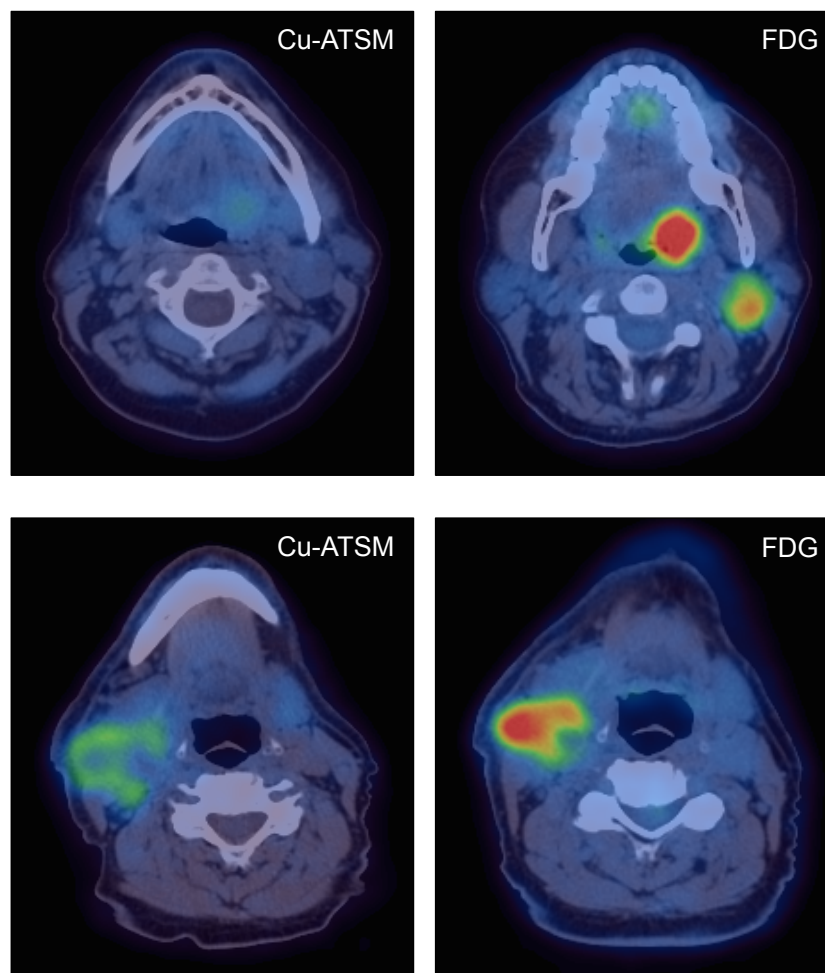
Comparison of ^{64}Cu -ATSM PET/CT with ^{18}F -FDG PET/CT.
